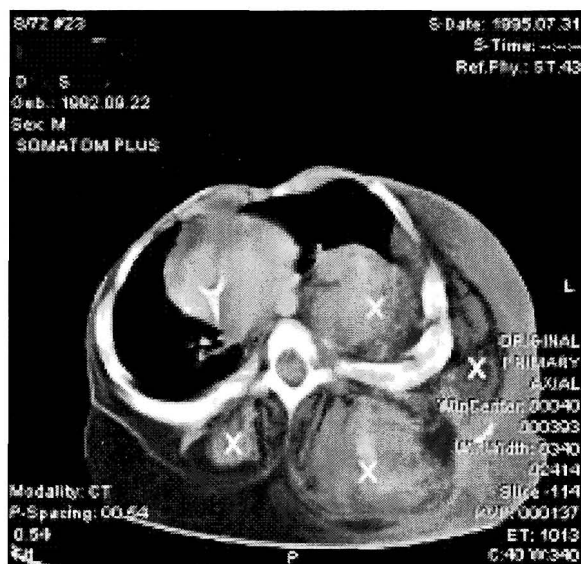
Multiple lymphatic malformations (x) and a chest wall deformation are clearly seen under computed tomography scan, July 31, 1995.
